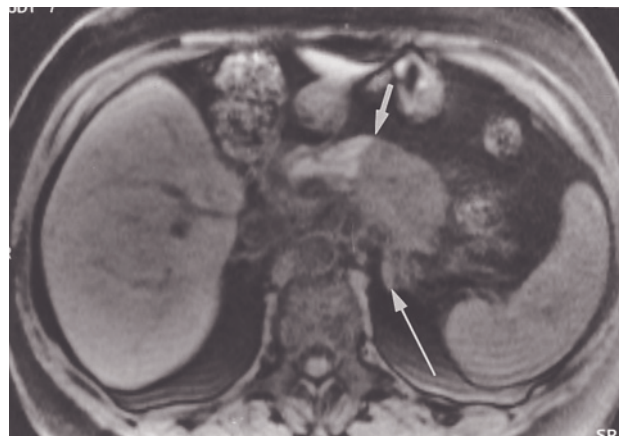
(*Continued*) the midpancreatic body. A sharp transition is apparent between proximal normal pancreas and tumor (arrow, *b*), which causes distal chronic pancreatitis on T1-weighted fat-suppressed images (*b*) and postcontrast images (*c*, *d*). A claw sign is appreciated (arrow, *d*), reflecting that the mass arises from the pancreas. Dilated ectatic pancreatic duct side branches are present in the distal body and tail, which enhances less than the normal parenchyma.
